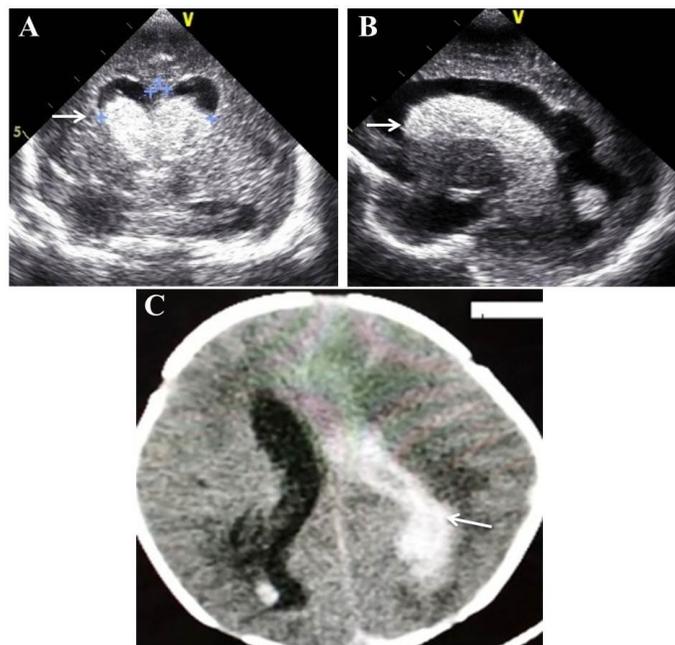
Transcranial ultrasound of A) coronal and B) sagittal views showing grade III intraventricular hemorrhage [arrows] (Note associated hydrocephalus); C) reconstructed non-enhanced computed tomography scan of brain showing grade III intraventricular hemorrhage filling left lateral ventricle [arrows] (Note associated hydrocephalus)
